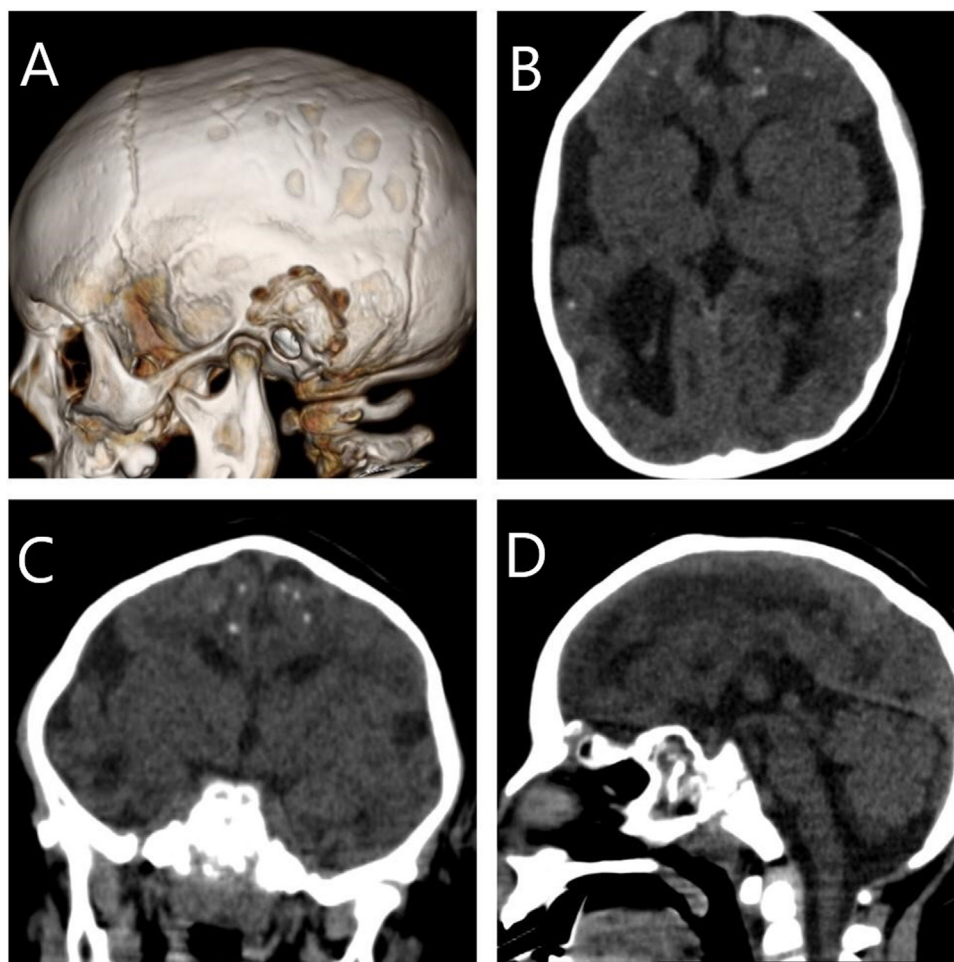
Computed tomography with lateral view of 3D skull reconstruction (A) and multiplanar reformattings (B, C and D – axial, coronal and sagittal, respectively) of the brain parenchyma, showing moderate brain volume loss, multiple parenchymal calcifications and malformation of the cortical development. São Luís, 2016–2018.
